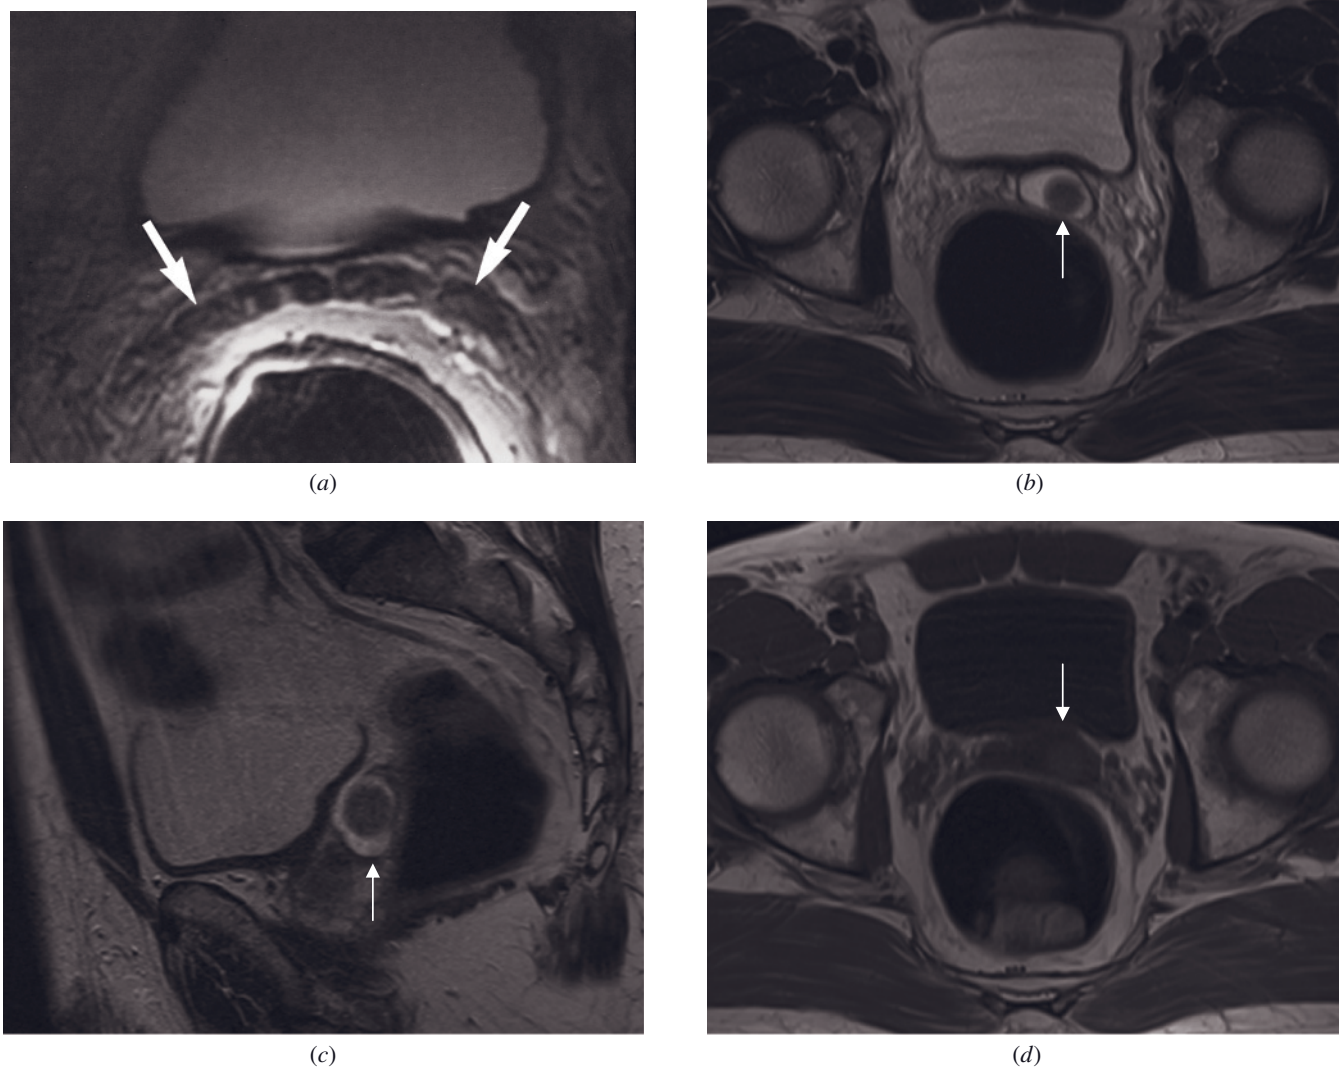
Amyloidosis of the seminal vesicles. Transverse T2-weighted ETSE endorectal coil image (a). There is bilateral decreased signal intensity of the seminal vesicles secondary to amyloid deposition (arrows, a). Seminal vesicle cyst and stone. Transverse (b) and sagittal (c) high-resolution T2-weighted images and T1-weighted fast spin-echo image (d) demonstrate a seminal vesicle cyst (arrows, b–d) in another patient. A stone, which shows low signal on T1- and T2-weighted images, is also detected in the cyst.
